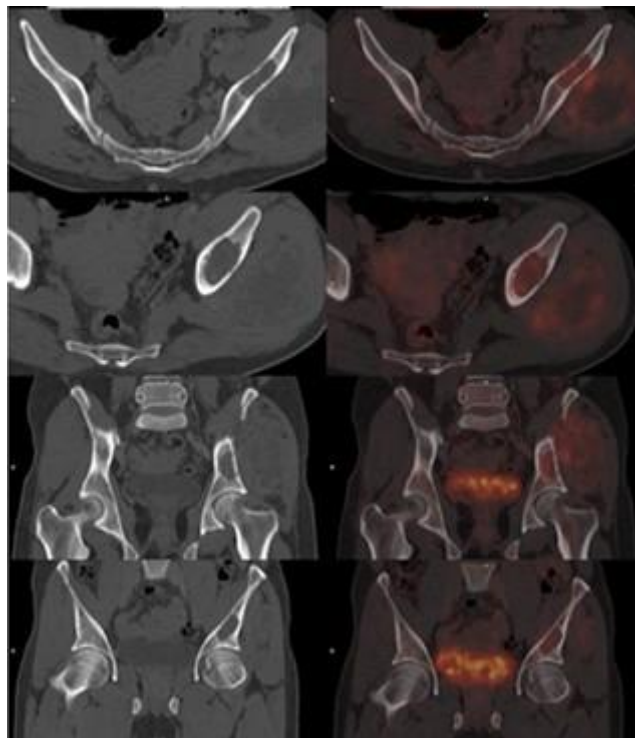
Multi-panel pelvic CT and fused PET–CT — FDG-avid lytic lesions in left iliac bone/acetabulum and large left gluteal soft tissue nodule (7.9 × 6.3 cm, SUVmax 8.9) with cystic/necrotic areas.
